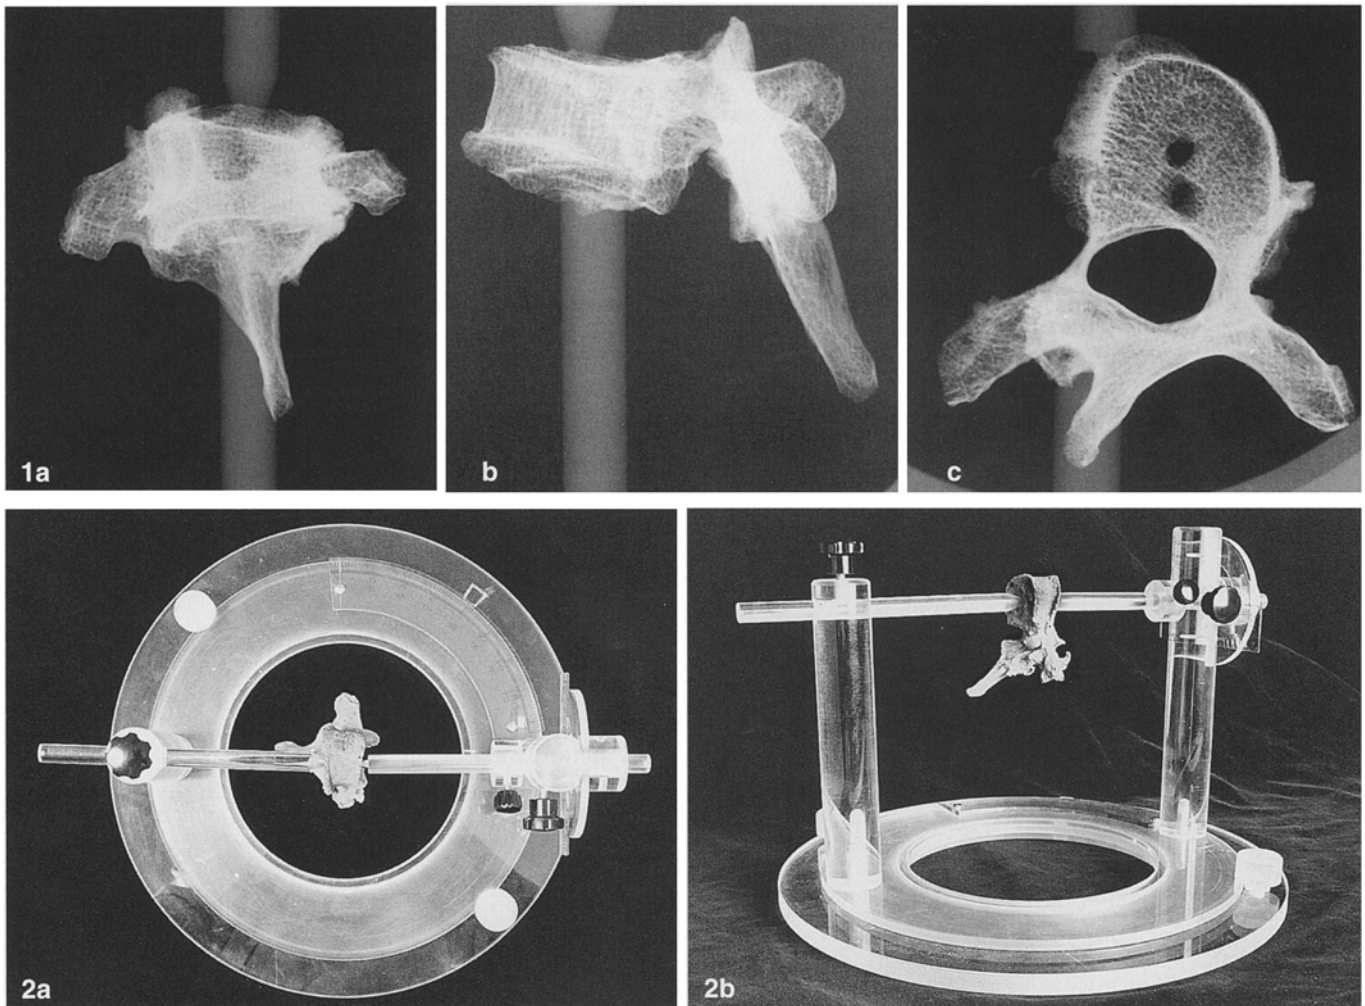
Radiographs in the frontal (a), sagittal (b) and horizontal (c) planes of the scoliotic vertebra in the model study
